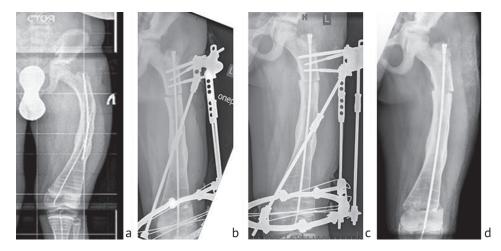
An instance of partial loss of deformity correction at the level of the proximal osteotomy showing (a) preoperative radiograph; (b) intraoperative radiograph; (c) an angular deformity of 7° developed at the level of the proximal osteotomy following compression forces created with the rings of the extrenal fixator; (d) radiograph of the femur after frame removal
